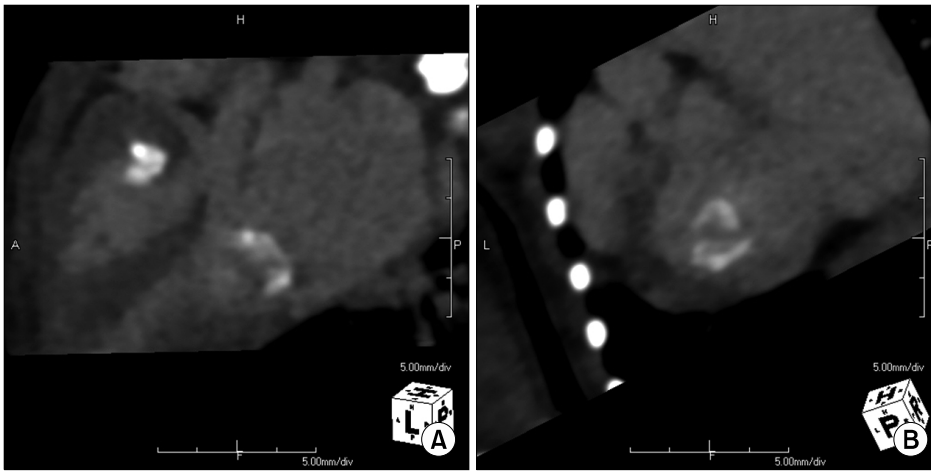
(A, B) Cardiac computed tomography showing calcified mitral and tricuspid valves.
